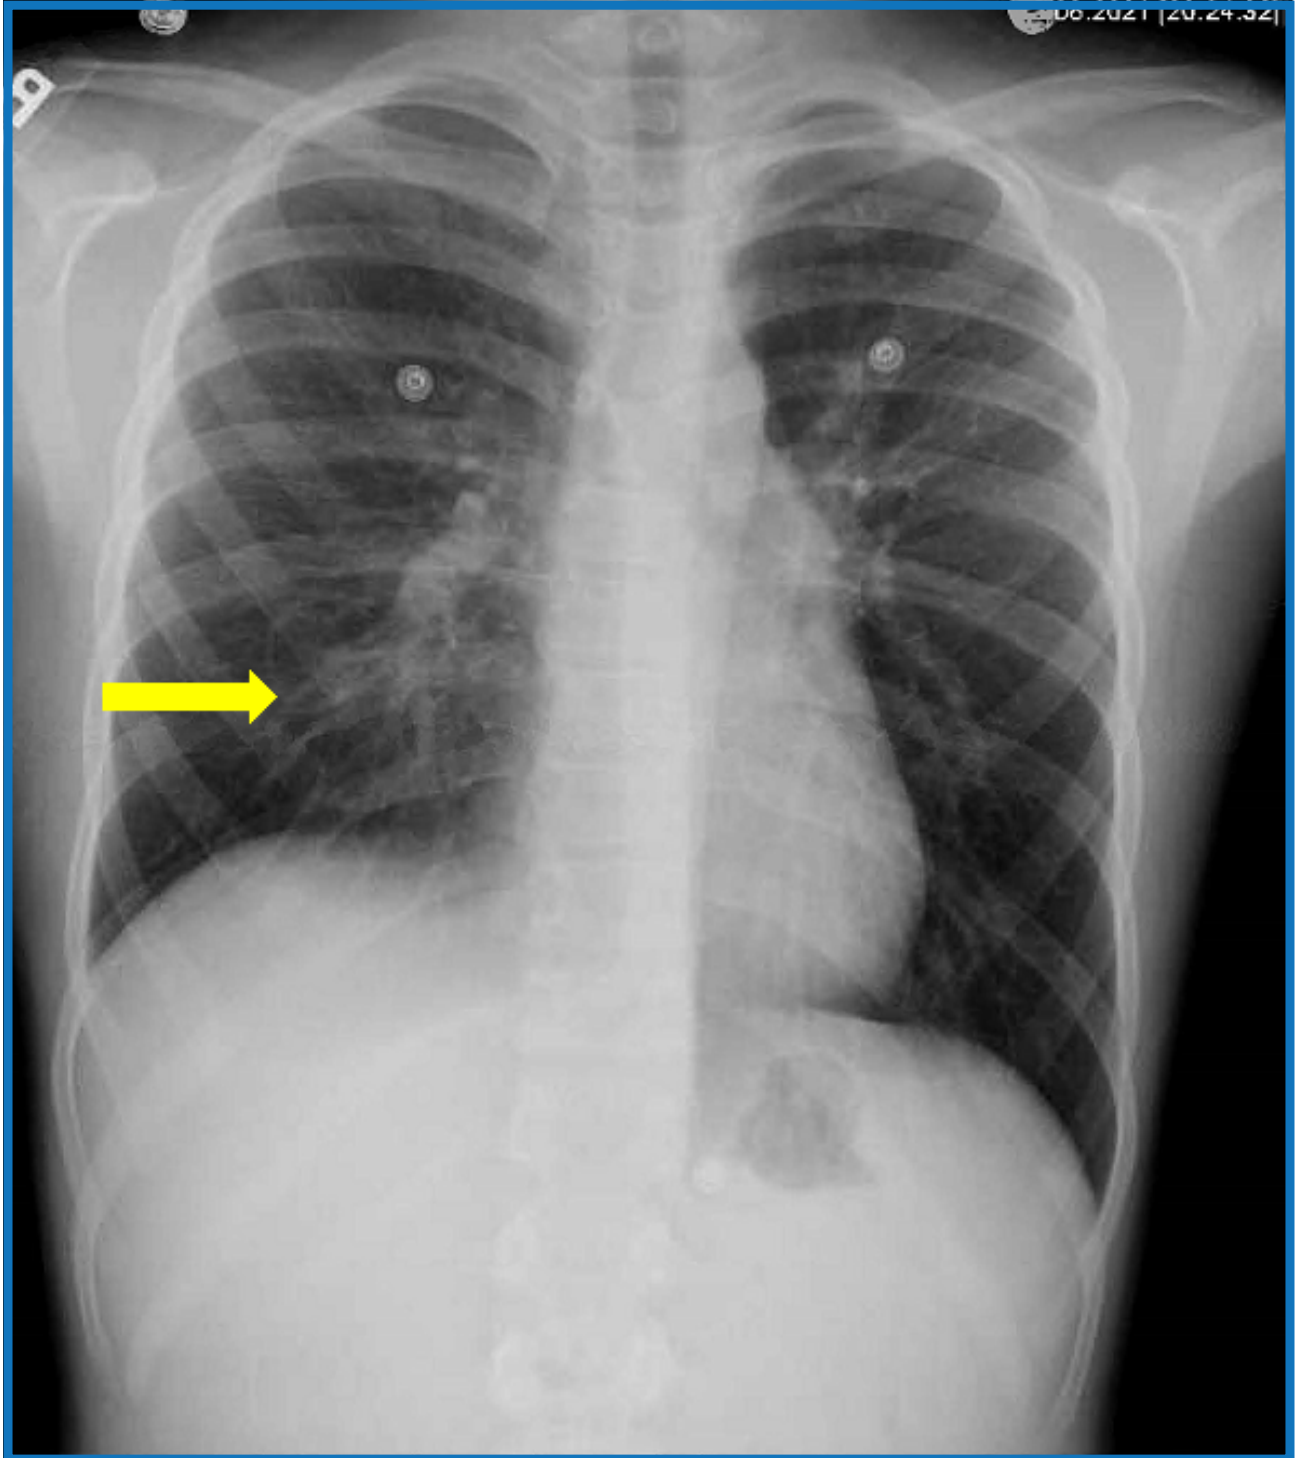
Chest X-ray showing a questionable pectus excavatum deformity, and patchy atelectasis or infiltrate of the right middle lobe.
